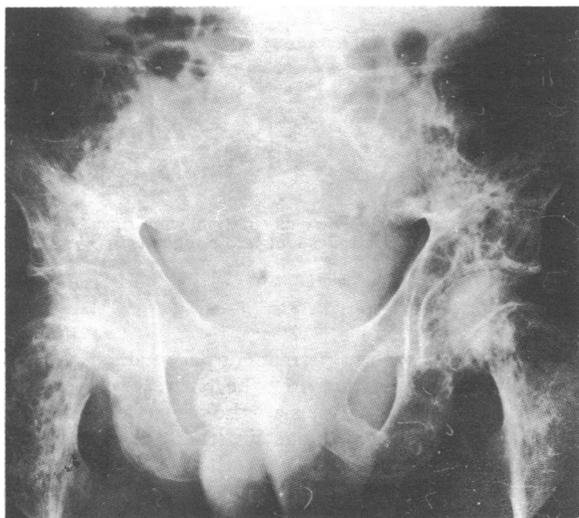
X-ray film taken October 1973 showing development of numerous areas of osteolysis with vertebral collapse.
